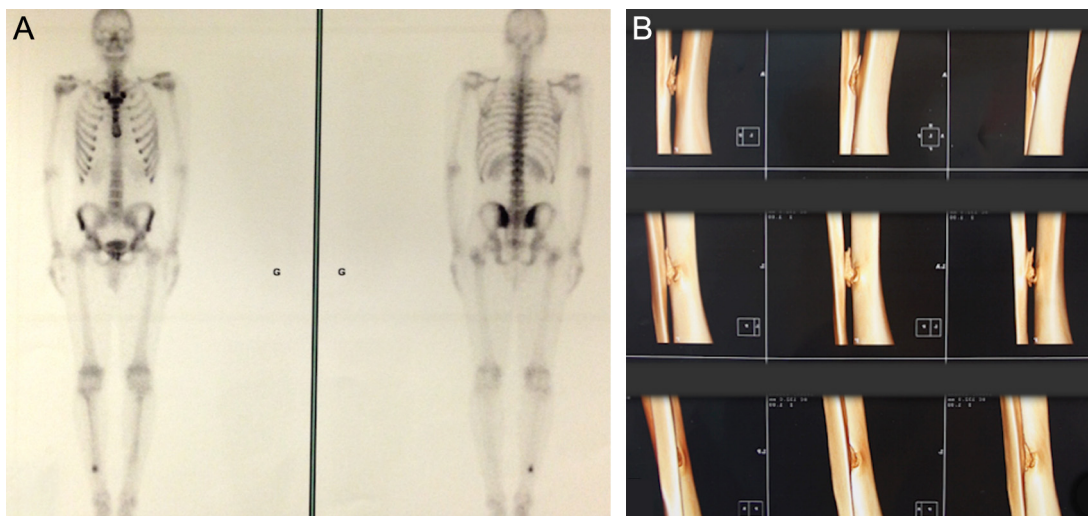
Case 2: A. Isotope bone scan, showing increased activity at the tibiofibular synostosis. B. 3D CT scan of the right leg, showing tibiofibular synostosis with vertical fracture.
